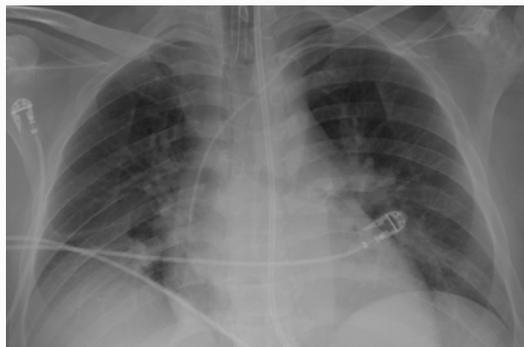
Donor's X-ray. Showing right lower lobe atelectasis.
